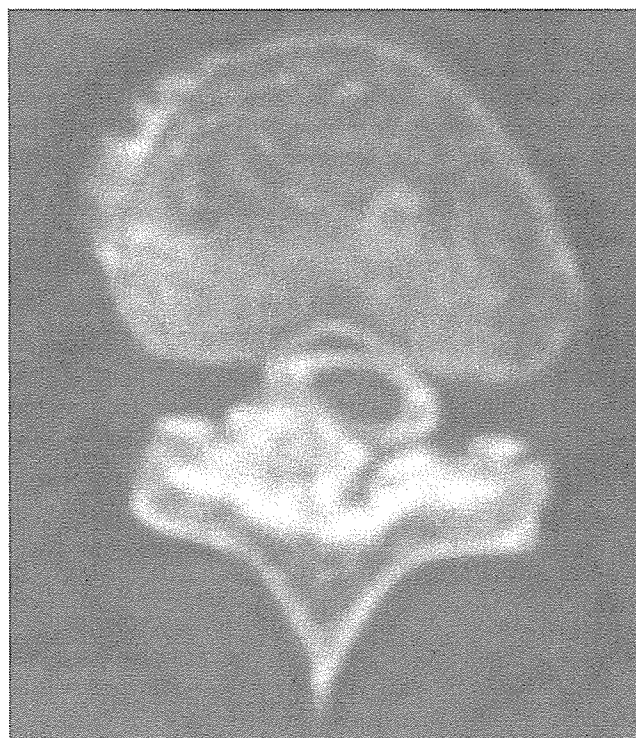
Preoperative CT myelogram obtained in a patient with OLF and ossified dura mater at the T10-11 level. The ossified ligamentum flavum adheres to the ossified dura on the right side of the spinal cord, and little contrast medium between the cord and ossified ligamentum flavum is detected.
